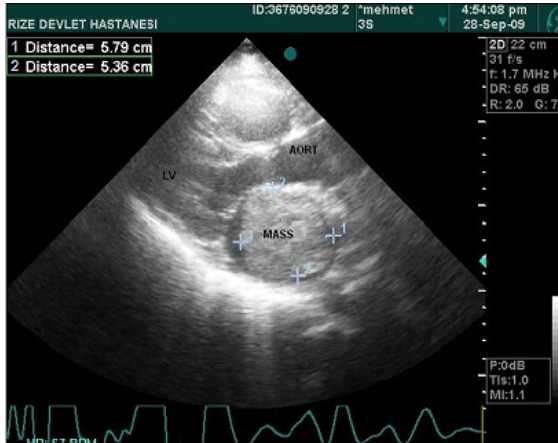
Giant left atrial myxoma, on parasternal long axis.
